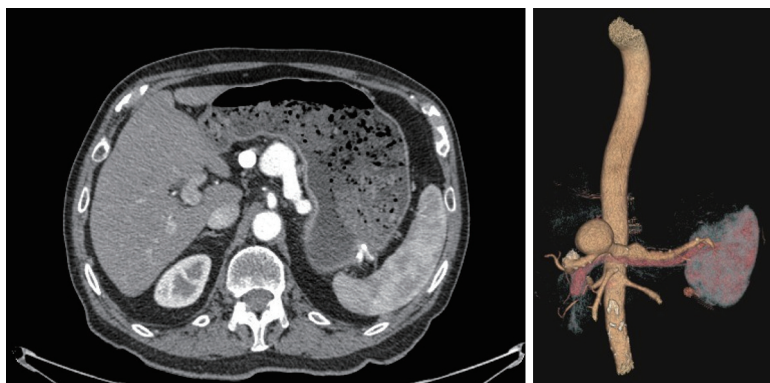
Abdominal enhanced computed tomography scan and angioscan showing a double aneurysm of splenic artery.
